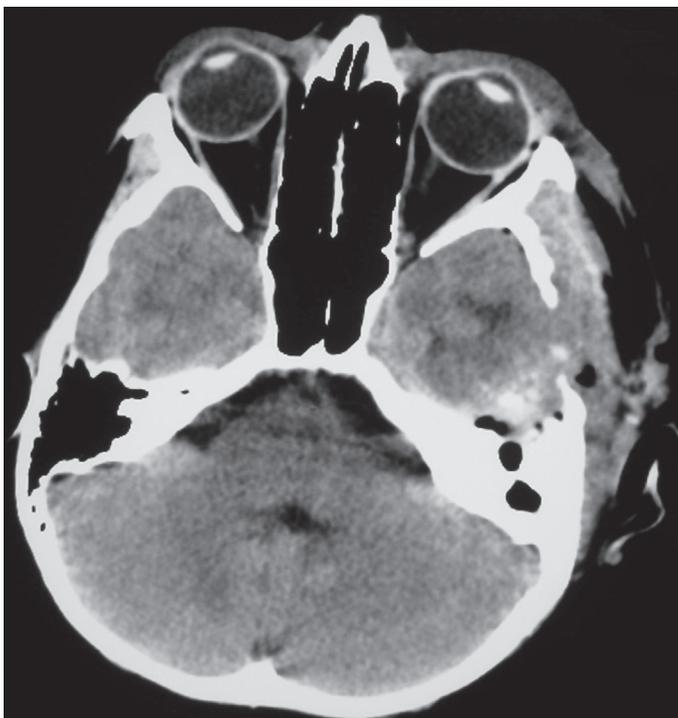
Post operation Computed Tomography scan
